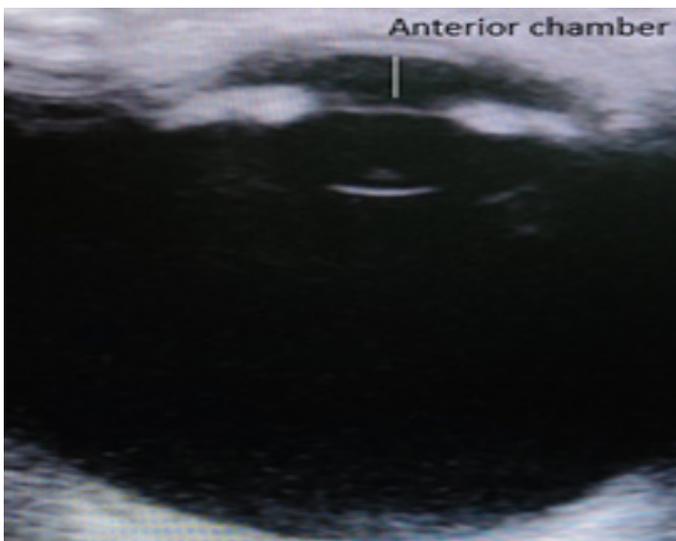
B-mode ultrasonography of the orbit
